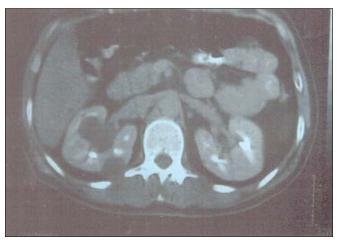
Axial contrast-enhanced computed tomography scan shows multiple cysts of bilateral kidney.
